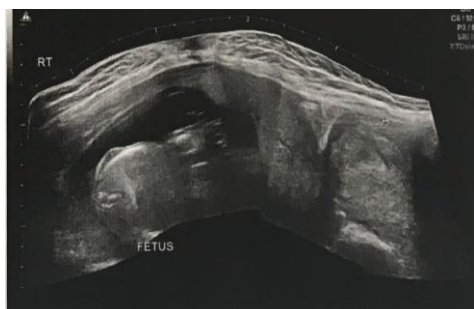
Ultrasound showing fetus in abdominal cavity with no surrounding myometrium
